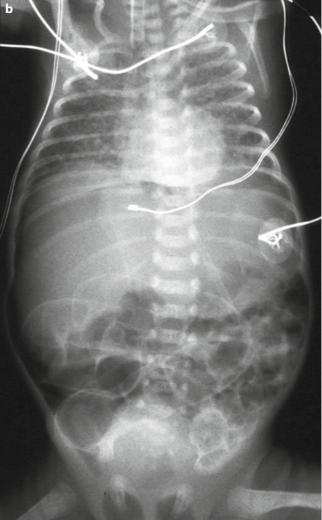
Radiographic appearance of pneumoperitoneum with liver displacement, presence of air along the abdominal wall (a) and presence of air in the scrotum (b)
